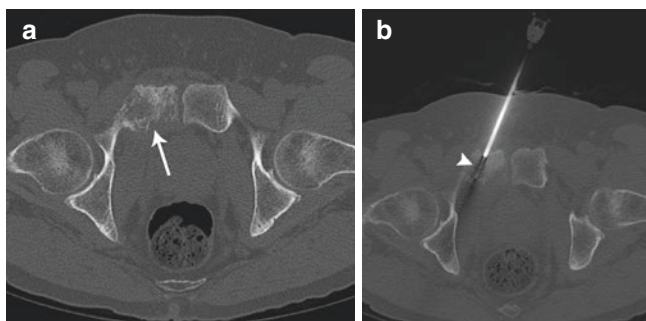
(a) CT-guided bone biopsy of a lytic and sclerotic metastatic lesion involving the pubis (*arrow*). (b) A coaxial bone biopsy system is introduced using an oblique approach (*arrowhead*)
